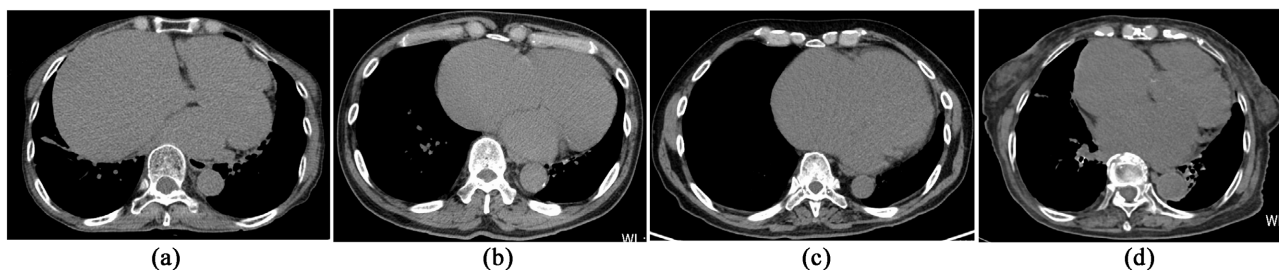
Preoperative chest computed tomography reveals dilatation of the right atrium in all cases ((a) case 1, (b) case 2, (c) case 3, and (d) case 4).
